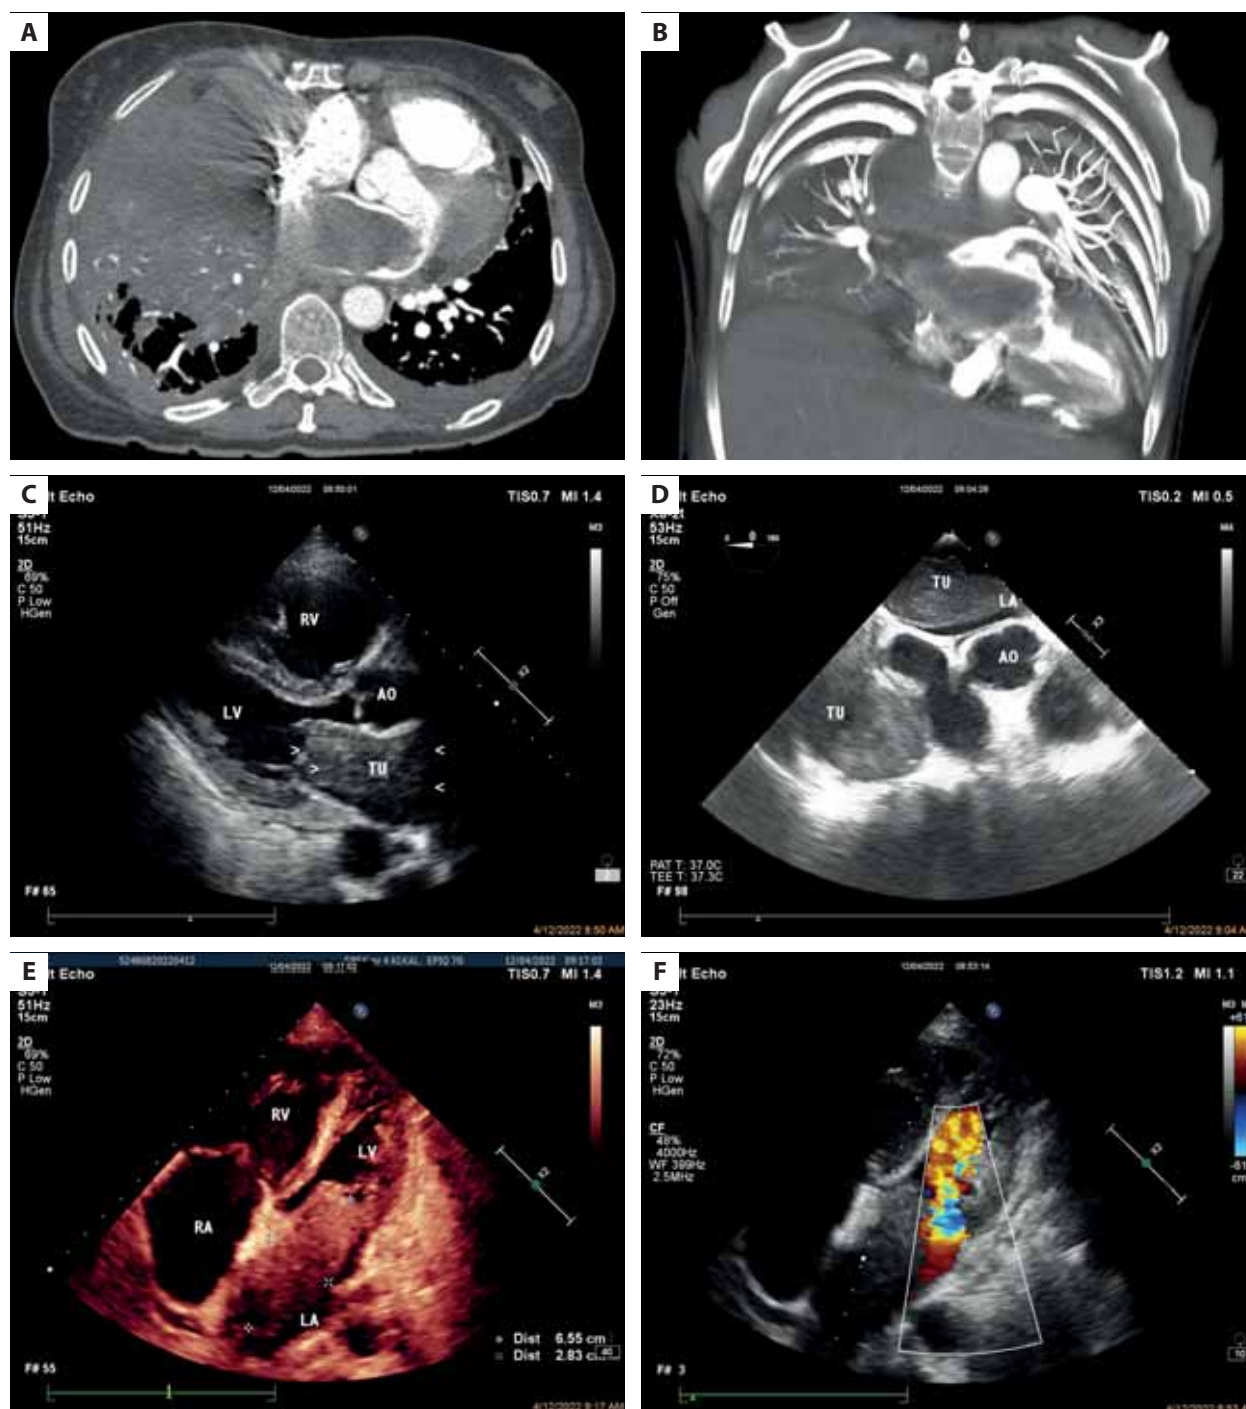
A. Axial projection of CT in the arterial phase. Extensive mass located in the right lung filling almost the entire left atrial cavity. A small amount of fluid in both pleural cavities. B. CT, 3D volume rendering presenting nodular masses in the mediastinum and the right lung, poor vascularization of the right lung, and a nodule mass passing from the LA to the LV. C. TTE, parasternal long axis view, tumor mass visible in the LA (arrows). D. TEE, aortic valve level, tumor visible in the right lung and the LA. E. TTE, apical 4-chamber (A4C) view, pathological soft-tissue mass visualized in the LA (6.5 cm × 2.8 cm), protruding through the mitral valve into the LV. F. TTE, Apical 4-chamber view, color Doppler, stenotic mitral flow due to the mass protruding into the LV
